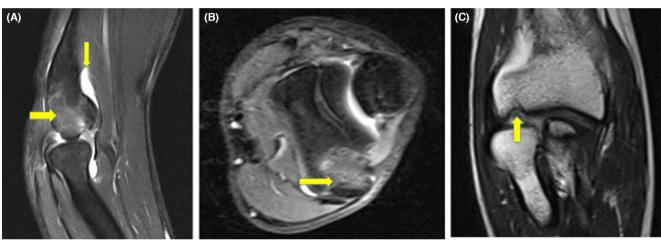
Magnetic resonance image (MRI) of the patient. (A) Sagittal view: Horizontal arrow shows bone edema, and Vertical arrow shows significant joint effusion. (B) Axial view: Arrow shows bone edema. (C) Coronal view: Arrow shows defect in joint surface
